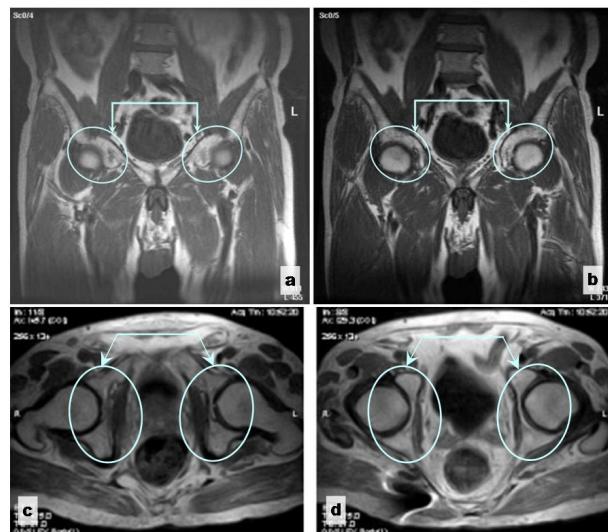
MRI T1 sequence: (a-b): Core; (c-d): Axial.
